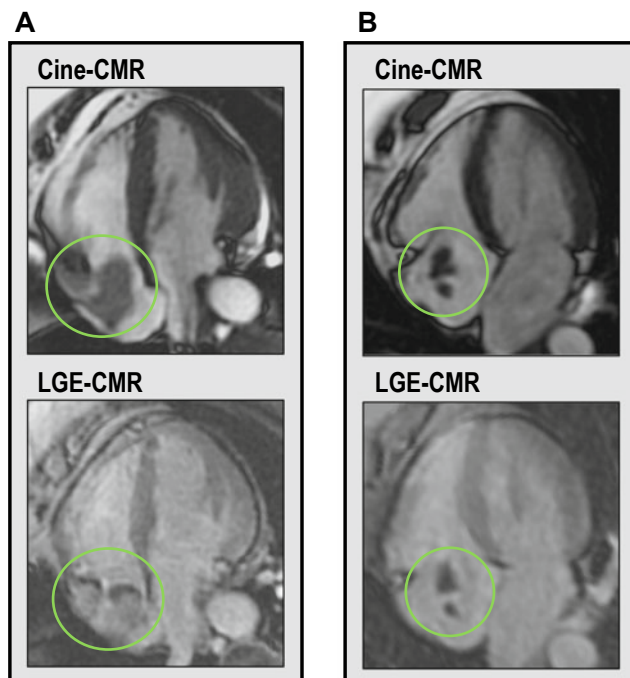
Right atrial masses on cardiac MRI: a Still frames from cine-CMR showing tumor appearing as bilobed right atrial mass (top panel) with long inversion time (TI) on late gadolinium enhancement (LGE-CMR) (TI 600 ms) in bottom panel compared with thrombus b that has a similar appearance to tumor on upper panel cine-CMR but clearly showing no late gadolinium enhancement on lower panel. The mediport catheter tip associated with this thrombus was not seen on these MRI slices.
